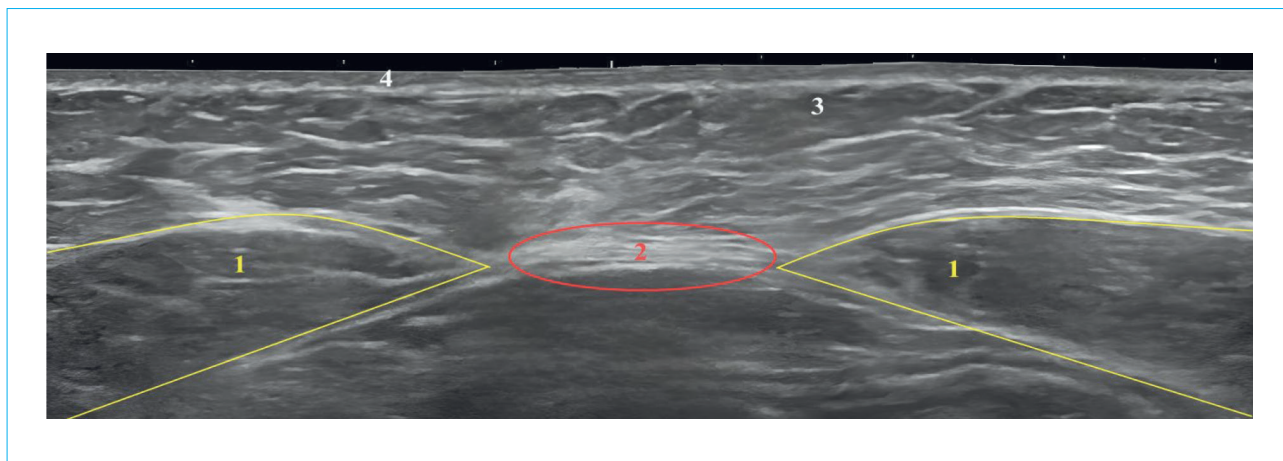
Structure of the anterior abdominal wall at ultrasonography: 1 — anterior rectus abdominis muscles, 2 — linea alba, 3 — subcutaneous adipose tissue, 4 — skin
